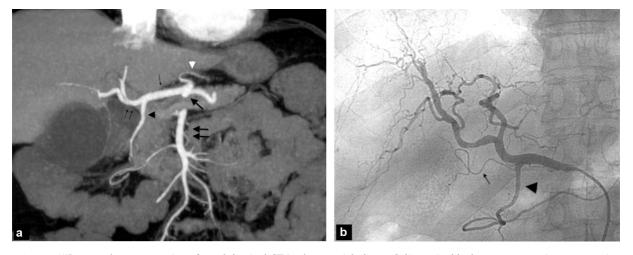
a: MIP coronal reconstruction of an abdominal CT in the arterial phase. Celiac axis (black arrow), superior mesenteric artery (double black arrow), common hepatic artery (small arrow), gastroduodenal artery (black arrowhead), main hepatic artery (double small arrow), left gastric artery (white arrowhead); b: hepatic arteriography with opacification of the common hepatic artery, showing the gastroduodenal artery (arrowhead) and cystic artery (arrow). Note the presence of many gallstones.
